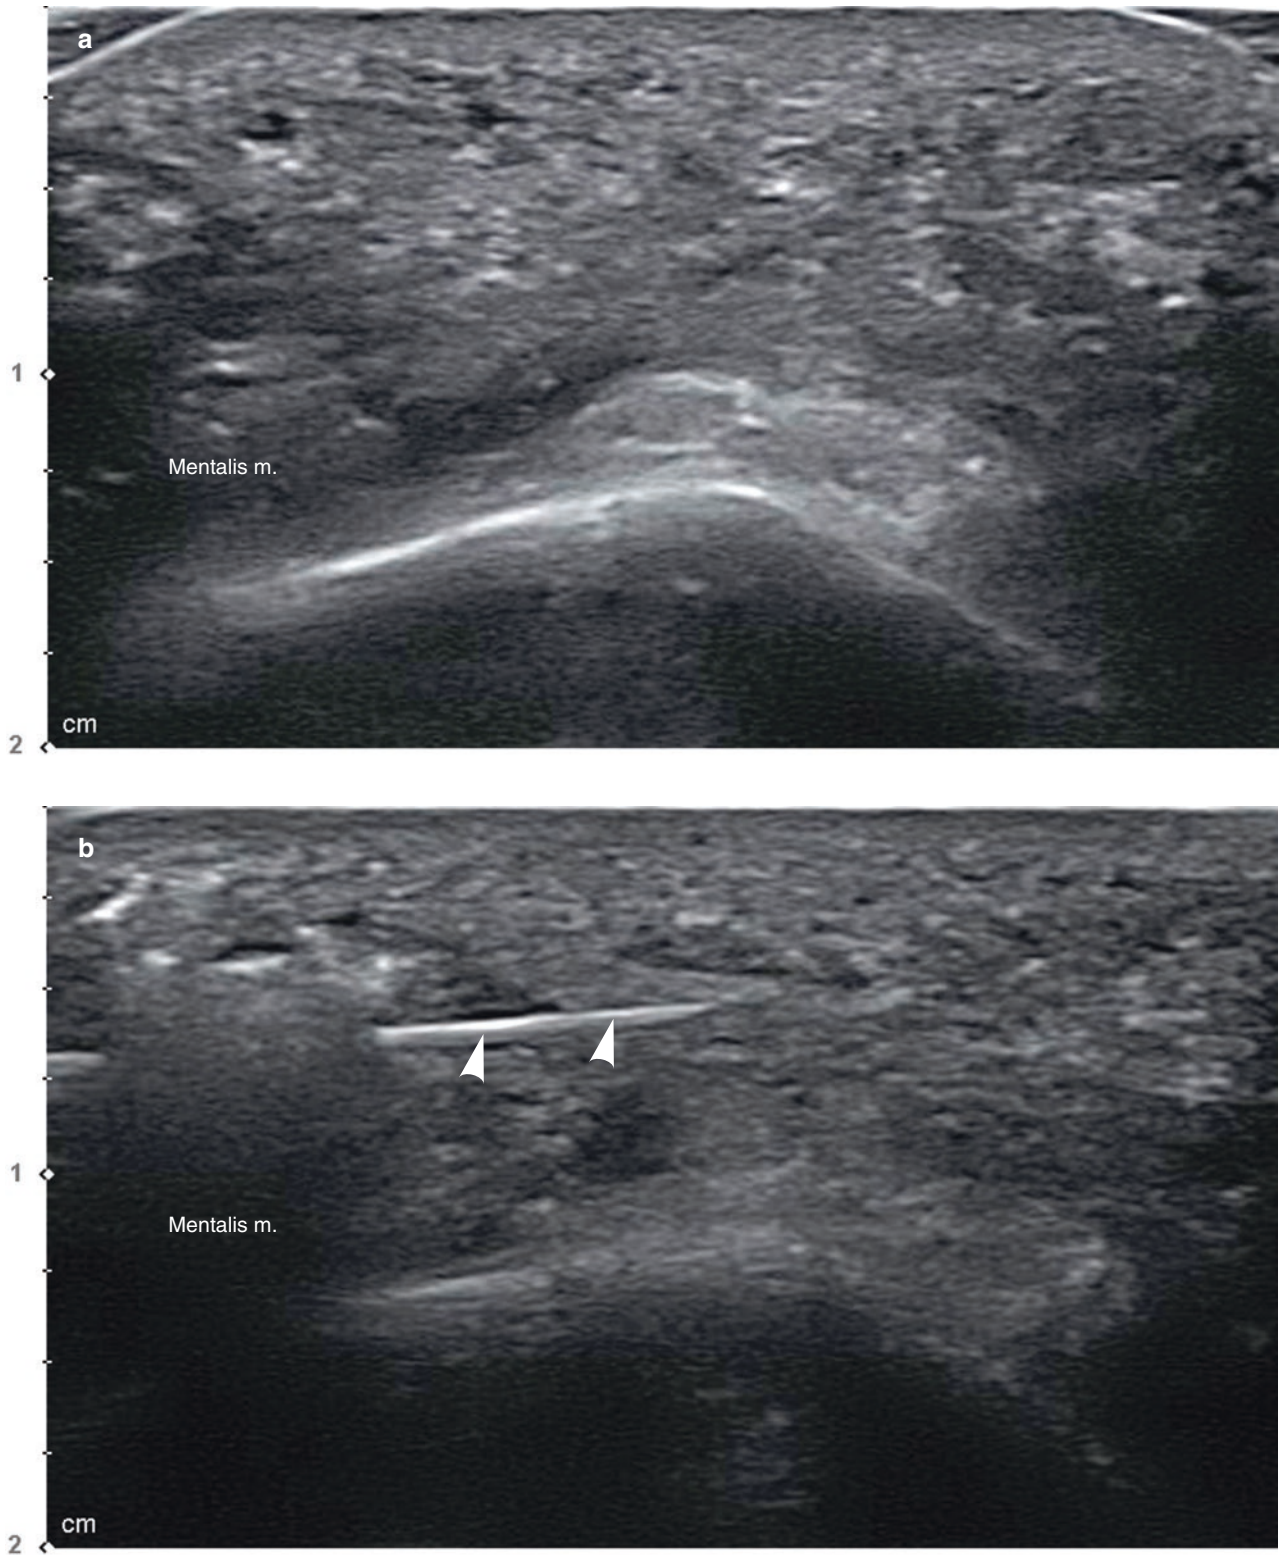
Ultrasonography-guided HA filler removal on the chin. (a) Before injection, B mode (transverse view, 15 MHz by linear transducer) and (b) during injection, B mode (transverse view, 15 MHz by
